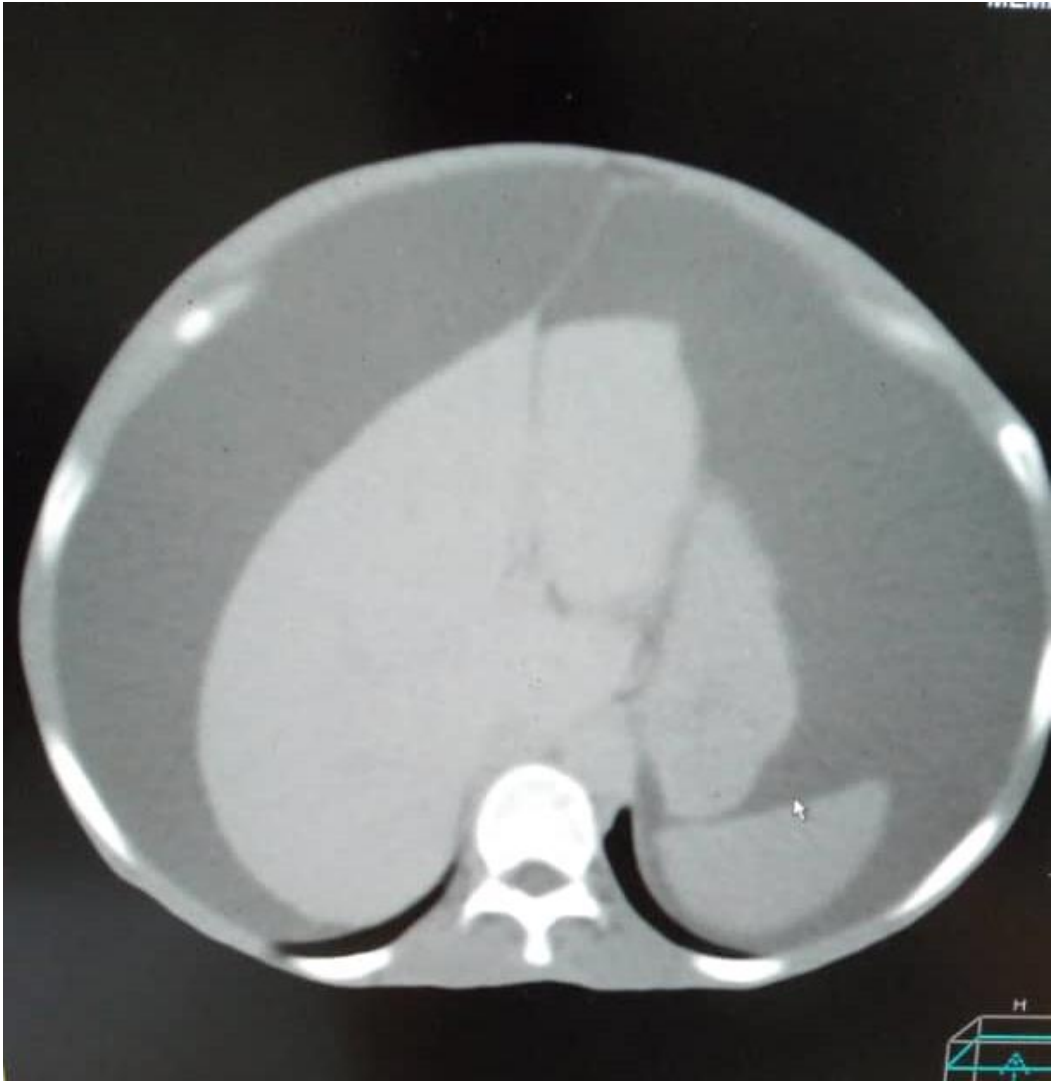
axial CT image of the abdomen demonstrating severe ascites
